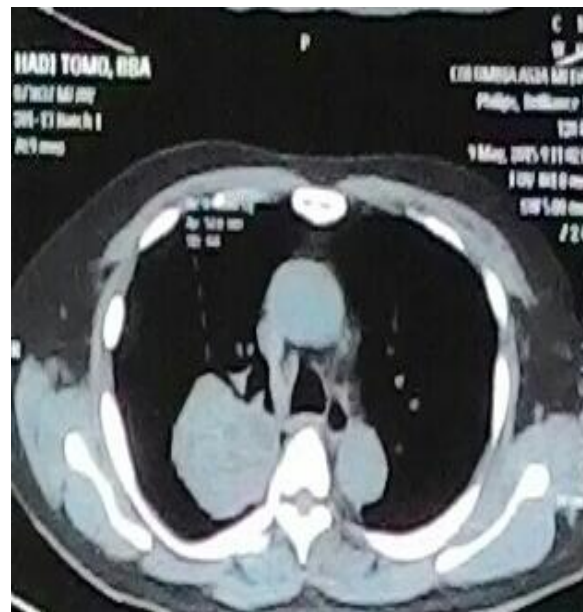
CT scan of the thorax pieces Axial
